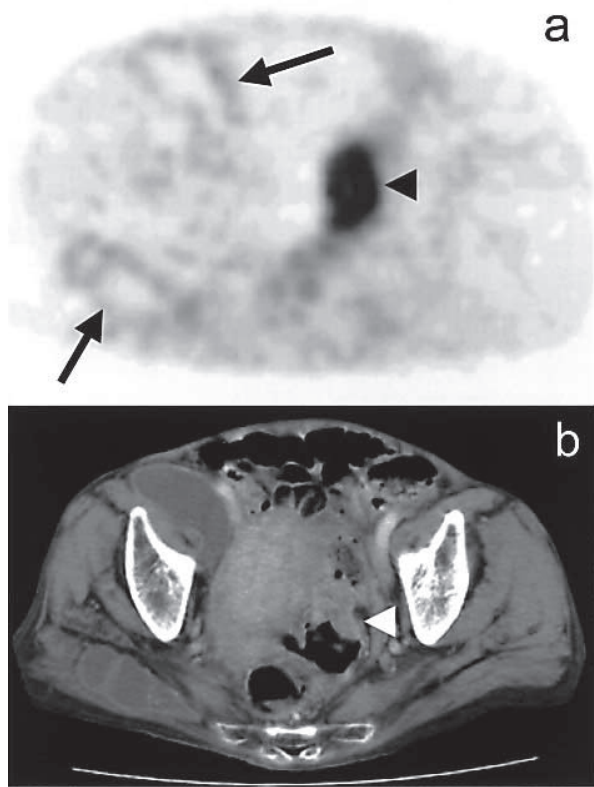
Case 1, FDG PET(a) showed moderate uptake in the capsule and low uptake in the center of the tuberculous abscess (*arrows*), and intense accumulation corresponding to rectal cancer (*arrowhead*). Benign myoma uteri in CT showed no FDG uptake in PET. Contrast-enhanced CT (b) showed right inguinal and gluteus abscess with thin capsule and mass lesion of the rectum (*arrowhead*).
